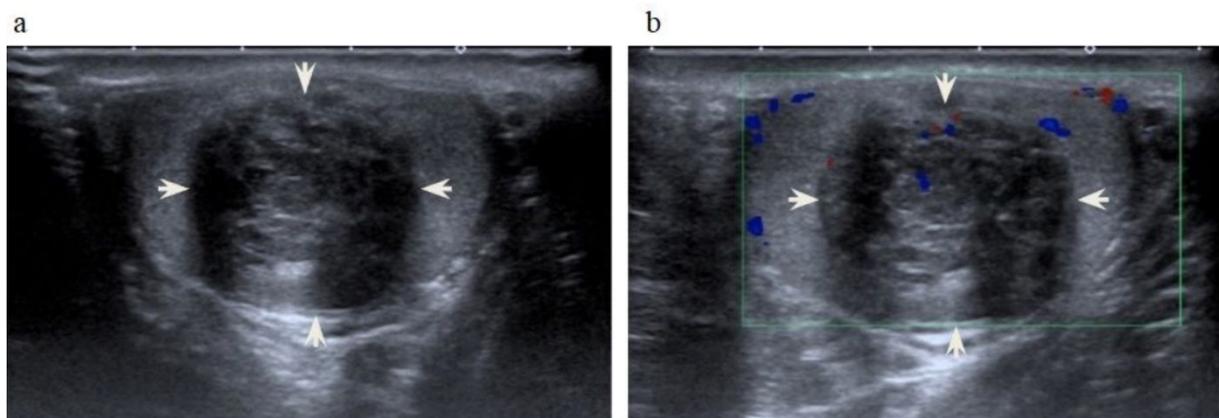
B-mode USG shows a well-bordered, round, heterogeneous, and solid mass lesion with echogenic areas inside the testicle, 1b. Doppler USG reveals the vascularization inside the mass and its periphery
